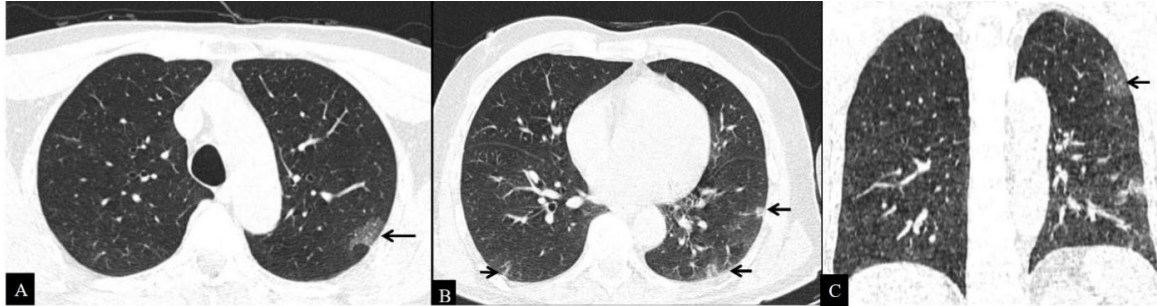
(A-C): Axial (A-B) and coronal (C) non-contrast CT scan sections in lung window of a 60-year-old unvaccinated male patient show multiple areas of ground glass attenuation in bilateral lungs with peripheral predilection (blue arrows) along with subpleural bands in the right lung (black arrow). The patient had a CTSS of 15 (moderate disease).
